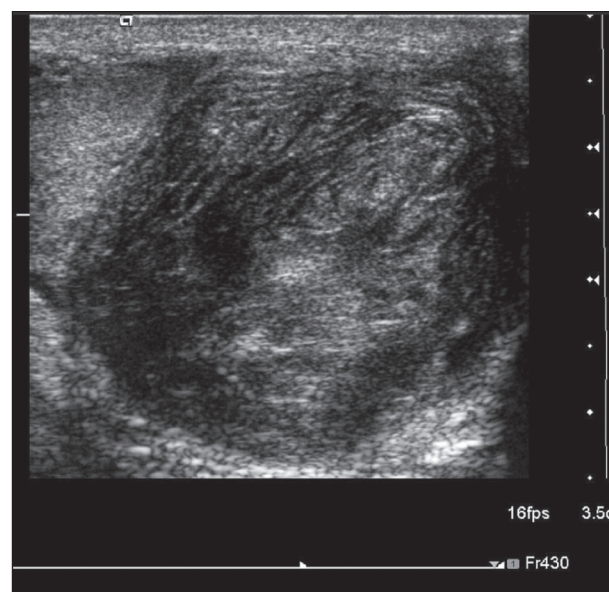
Sonogram LS shows the leiomyoma distal to the testis
